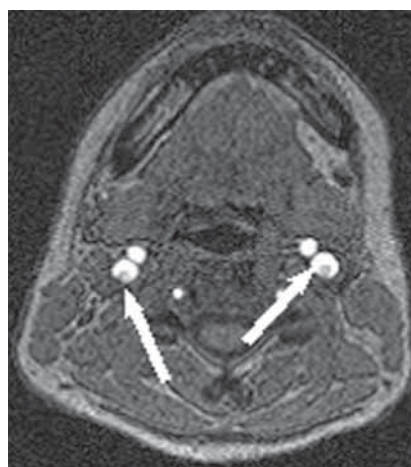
MRI – angiography (TOF sections) nonspecific blood flow modifications – augmented image in the right – both internal carotid arteries have a “semilune” pattern
